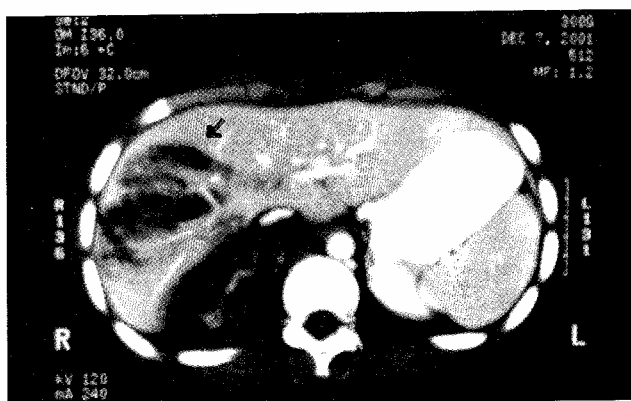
Computed tomogram of the abdomen showing a radiating laceration of the right hepatic lobe grade IV (Bear Claw type).
